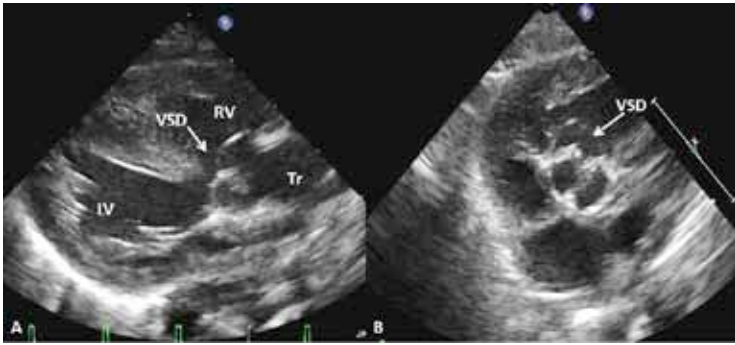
A. Parasternal long axis view showing truncus (Tr) overriding the ventricular septum and ventricular septal defect (VSD) (arrow). B. Parasternal short (B) axis view demonstrates the VSD in the conal septum. LV, left ventricle; RV, right ventricle.
